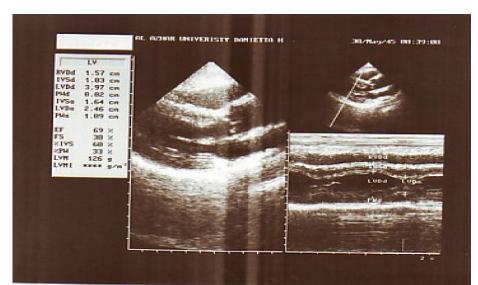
ECHO studied fore female patient, 43 years, with RA since 6 years, showing left parasternal long axis view and M mode showing asymmetrical hypertrophy of the left ventricle (hypertrophic cardiomyopathy (HCM).
